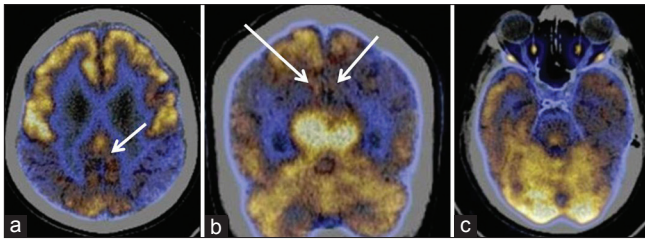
(a) Transaxial fused FDG-PET/CT images of the same case of MCI progressed to AD with MMSE of 20 now showing hypometabolism in the both parietal and posterior cingulate cortices (arrow). (b) Coronal fused FDG-PET/CT image showing hypometabolism in both precuneus L > R (arrow) and parietal cortices. (c) Transaxial fused FDG-PET/CT images showing hypometabolism in the both temporal (R > L) cortices
